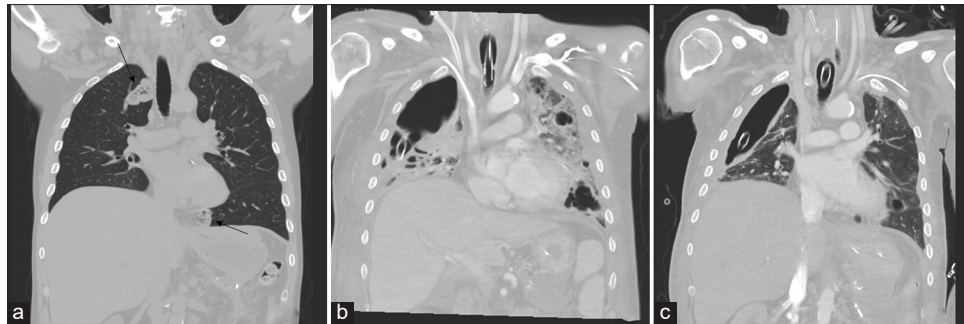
Chest CT of the patient at each point of the treatment period (a-c). CT: Computed tomography
